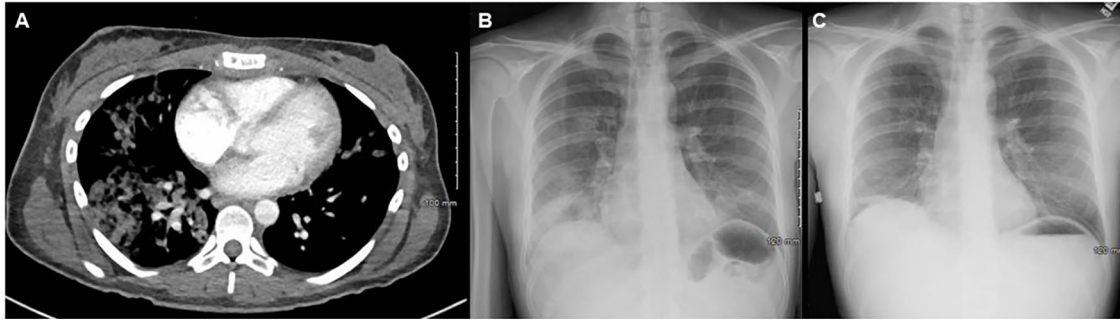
Lung imaging confirming pneumonia in our patient: A computerized tomography (CT) of the chest (A) showing bilateral airspace opacities predominantly throughout the right, upper-middle, and lower lobes as well as the lingula. The opacities appear confluent in the right lower lobe with no cavitation observed. The location is perihilar and likely peripheral in the right. No pleural effusions or endobronchial lesions are seen, (B) a chest X-ray showing patchy airspace opacities at the lung bases with additional multifocal opacities predominantly evident in the right upper and left lower lung zone. No pleural effusion or no pneumothorax was observed. Cardiac and mediastinal borders were within normal limits, and (C) a follow-up X-ray image (day 6 after admission) showed improvement of the infection post antifungal administration.
